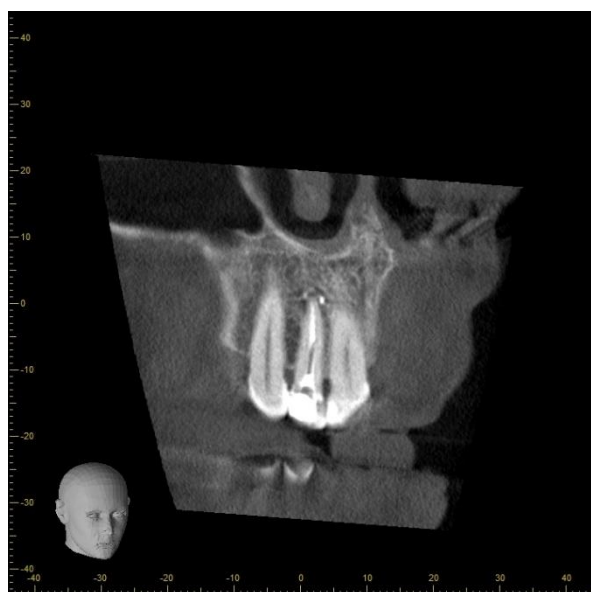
Y slice of CBCT scan
